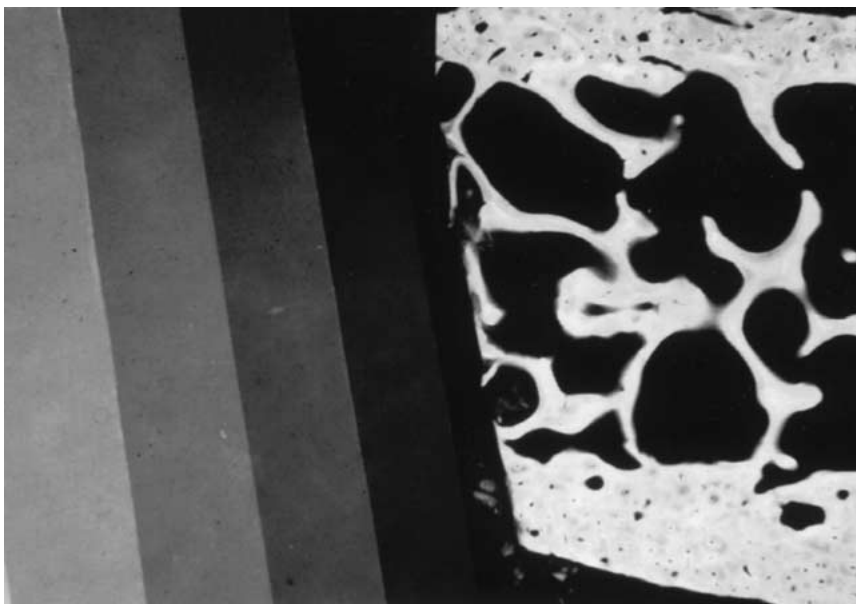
To allow quantitative evaluation of microradiographs, each bone section is exposed to X-ray concomitantly with an aluminum step-wedge ($\times 10$).
